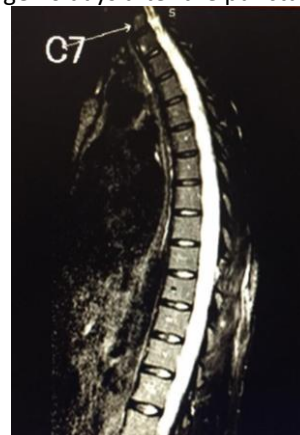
Cervical-thoracic-lumbar magnetic resonance imaging (MRI) in STIR sequence, sagittal plane, with presence of a foreign body emitting hypersignal of T9-T12.
